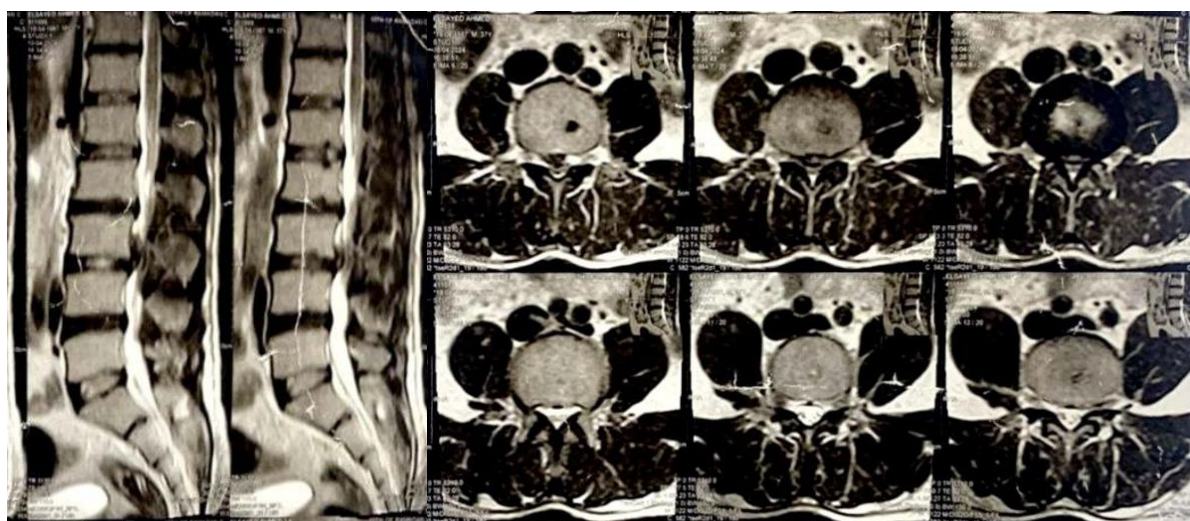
Preoperative MRI T2 lumbosacral spine sagittal and axial views showing L3-4 central stenosis and left lateral recess and foraminal stenosis.
